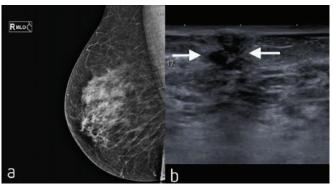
FFD Mammogram showing a moderately dense breast that obscures a clinically noted medial breast nodule (a) and ancillary imaging with ultrasound (b) confirming the presence of a small cancer (arrows).
